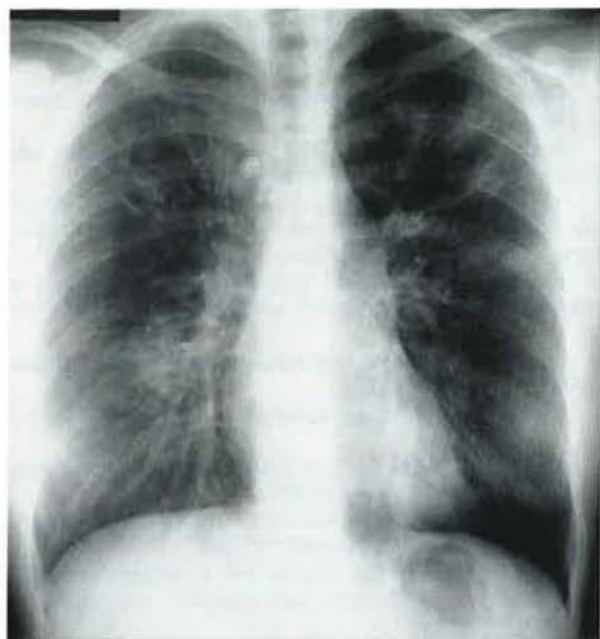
Chest radiograph taken on admission showing bilateral infiltrates.
